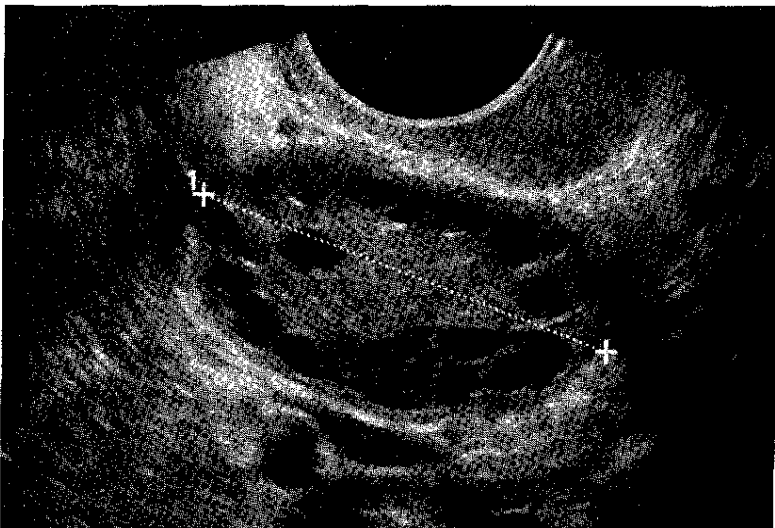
Ultrasonography of Polycystic Ovary with "String of Pearls" Appearance of Follicles
